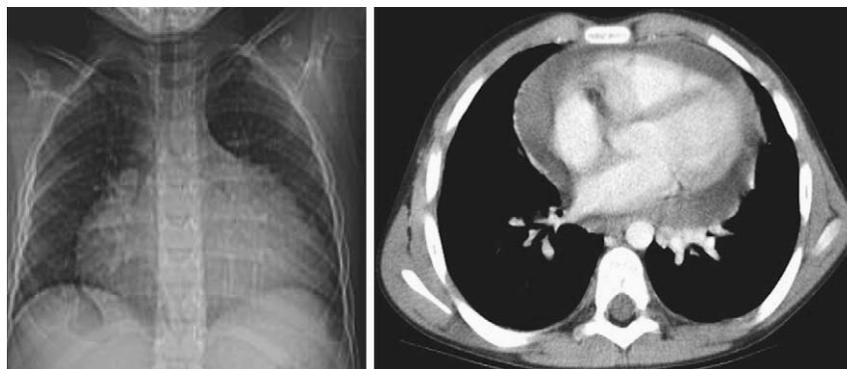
An enlarged cardiac silhouette on chest X-ray caused by massive pericardial effusion confirmed on chest CT.
